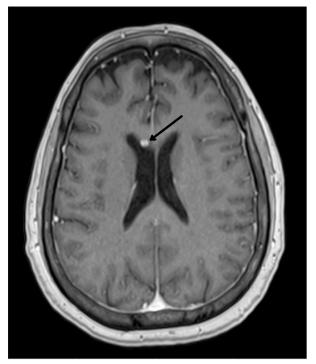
Magnetic resonance imaging (MRI) of the brain before treatment. Multiplanar multisequence MRI images of the brain with intravenous gadolinium. An enhancing 6 mm nodule of the right corpus callosum (arrow) is shown, indicating intracranial metastasis. There is no sign of intracranial hemorrhage.
